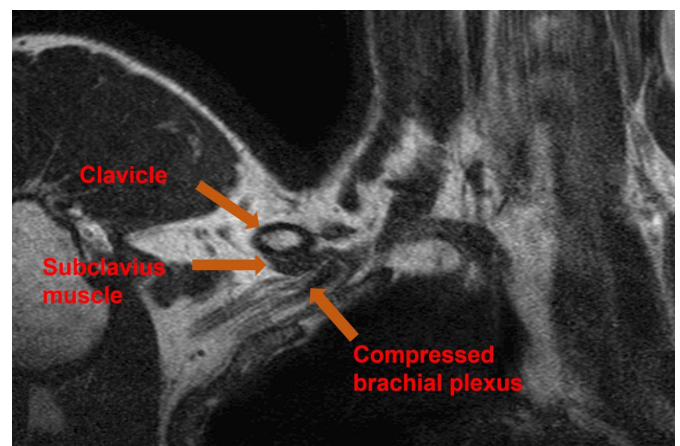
Magnetic resonance imaging in shoulder abduction position.
